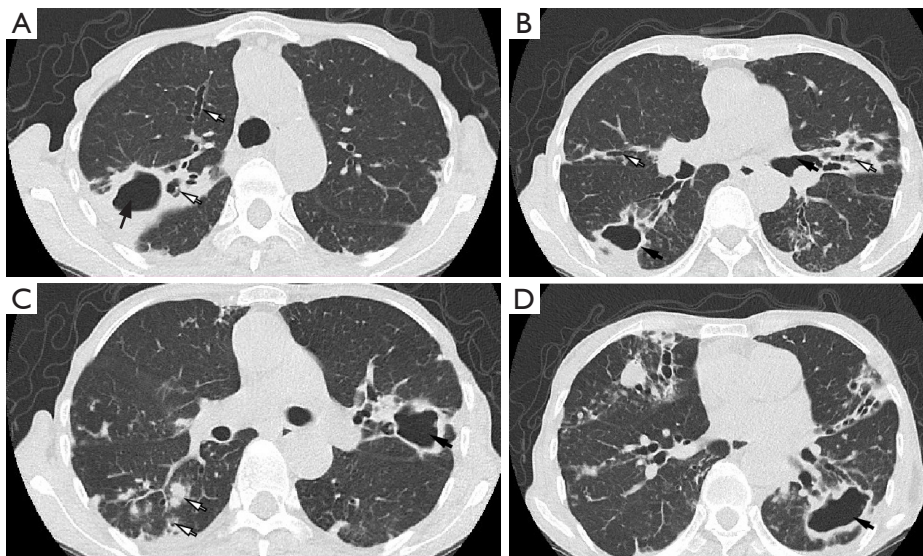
CT of a case of NTM (male, 68 years old). (A-D) Multiple sites of severe bronchiectasis in both lungs. Multiple thick-walled cavities are found in both lungs, and the inner walls of the cavities are smooth, and the cavities have a subpleural distribution. (A) An air-fluid level is seen in the cavity (black arrow) in the right upper lobe; (B) multiple bronchiectasis seen in the right middle lung lobe and left lingual segment (white arrow), cavity seen in the right upper lobe (black arrow); (C) the walls of the dilated bronchi are thickened, and multiple nodules can be seen around them, and lobular small central nodules (white arrows) can be seen in the lower lobe of the right lung; (D) dilated draining bronchi on the hilar side of the cavity (black arrow). CT, computed tomography; NTM, non-tuberculous mycobacteria.
